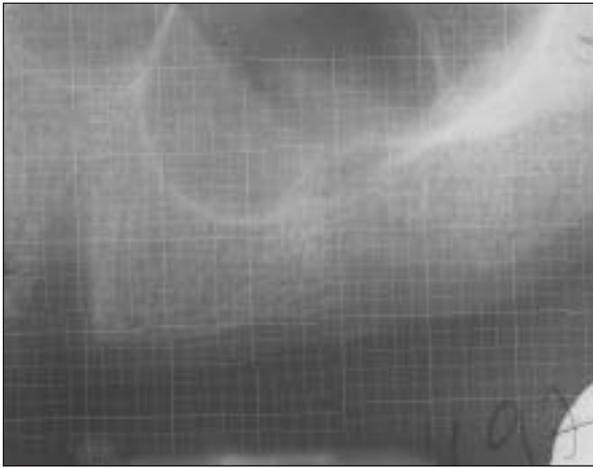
Preoperative radiographic image.
